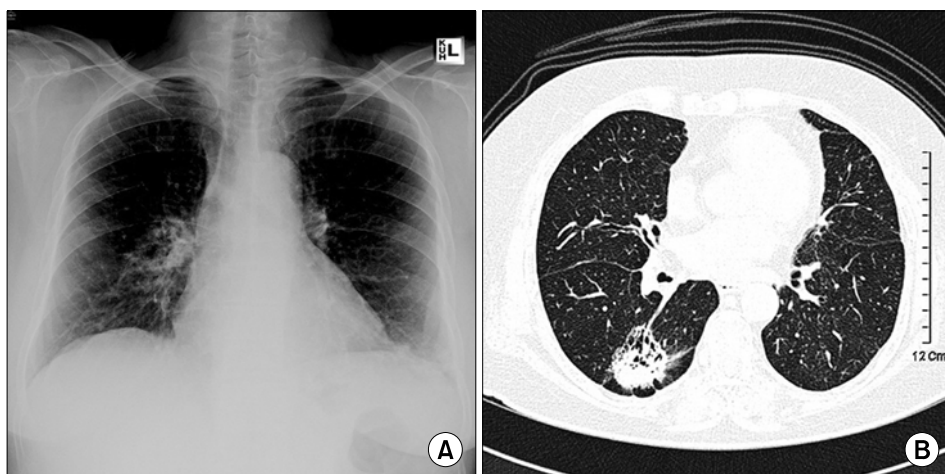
Chest radiography (A) and HRCT scan (B) taken 8 years after the initial presentation showing that the cavitary lung mass had increased in size and developed a solid portion.
